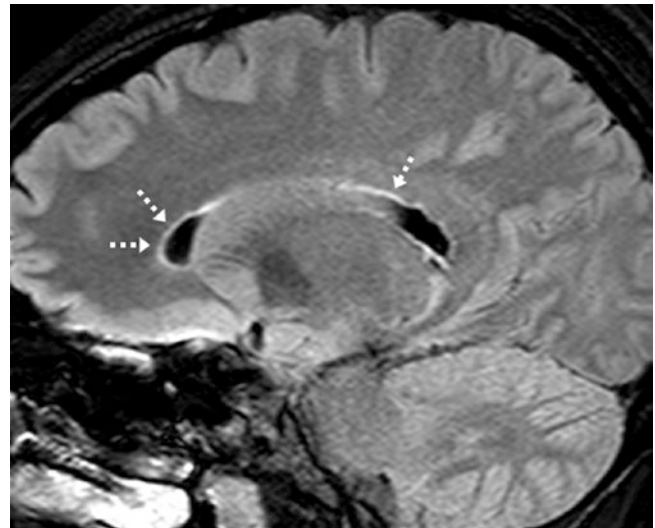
A 30 year old with normal subcallosal hyperintensity (*dashed arrows*) oriented parallel to the ventricles on a sagittal FLAIR image lateral to the corpus callosum
